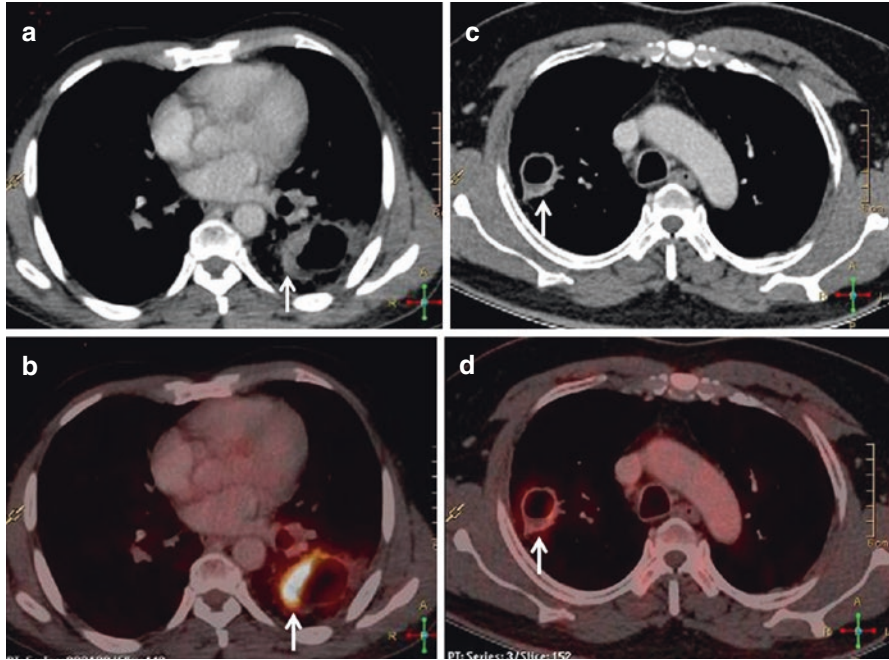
Cavitating lesions. Axial CT and fusion PET/CT (arrows in a, b) images in a patient of non-small cell lung cancer show a thick irregular walled cavity showing FDG uptake in the wall. Axial CT and fusion PET/CT (arrows in c, d) images in a patient of pulmonary tuberculosis show a thin-walled cavity
